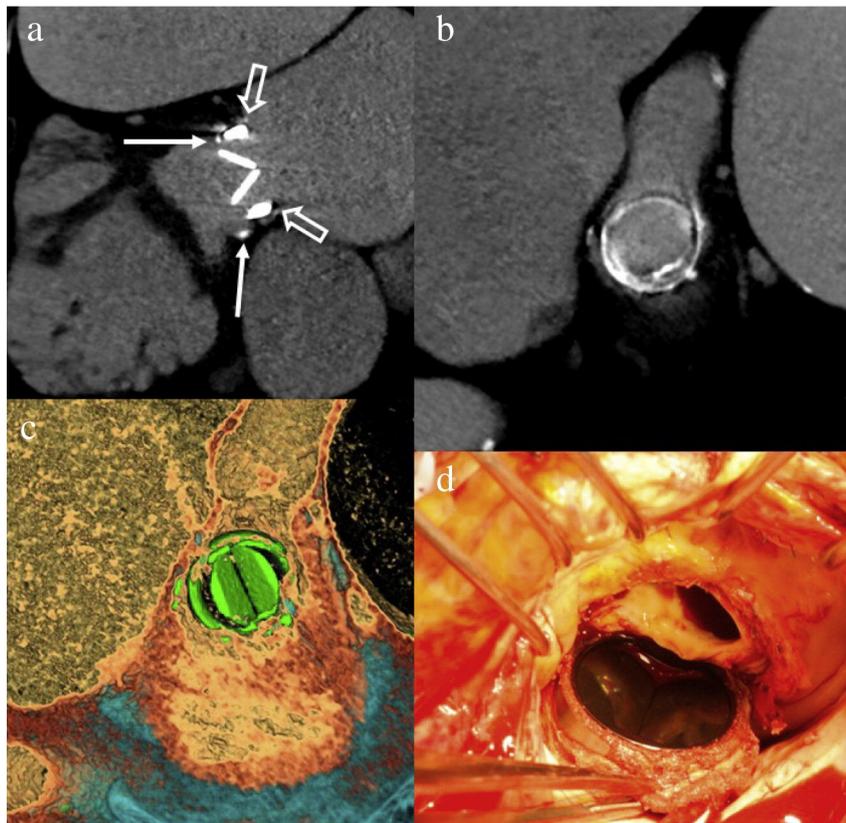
Long axis CT multiplanar reformatted image of a 59-year-old female patient with a 29-mm Carbomedics valve showing calcified perivalvular pannus around the prosthetic MV (a, arrows indicating the ventricular side and open arrows indicating the atrial side) with a restricted opening (opening angle 52° and manufacturer value 78°). She underwent MV replacement 37 years before the CT scan because of rheumatic heart disease. CT images from the left ventricular side (b, multiplanar reformatted image and c, 3D image) showing circumferential pannus formation around the prosthetic MV ring. She underwent redo-MV replacement surgery due to prosthetic valve obstruction caused by pannus, and (d) circumferential pannus was identified on the surgical inspection and resected. CT, computed tomography; MV, mitral valve.
